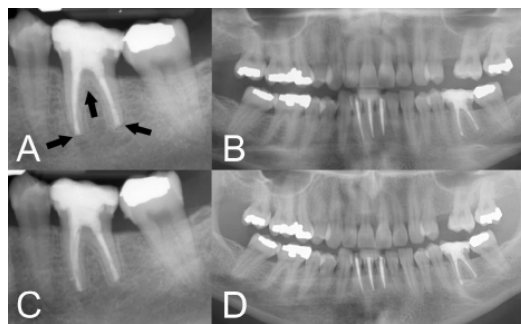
Medium-term follow-up radiographs demonstrate successful healing. A) Periapical radiograph at 3-year follow-up (2016) showing complete healing of the periradicular/interradicular lesions (black arrows), normal periodontal ligament space, and no signs of root resorption. B) OPG at 4-year follow-up (2017), confirming successful outcomes. C) Periapical radiograph at 5-year follow-up (2018) showing continued periapical health. D) OPG at 6-year follow-up (2019), confirming long-term success.
